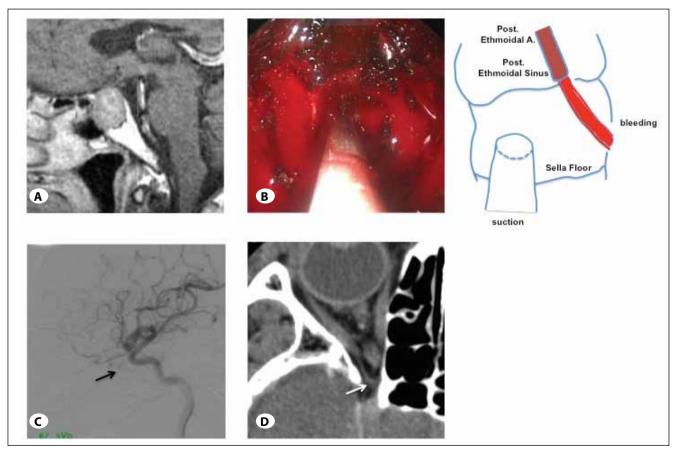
A) Sagittal view of gadolinium (Gd)-enhanced T1-weighted magnetic resonance images (MRI) showing an adenoma extending superior adjacent to the planum sphenoidale. B) Intraoperative endoscopic view showing the posterior ethmoidal artery (PEA) passing through the posterior ethmoidal sinus and actively bleeding (left). Scheme of the intraoperative endoscopic view (right). C) Lateral view of internal carotid artery angiography showed branching of the PEA from the ophthalmic artery and distributing to the posterior ethmoidal sinus. D) Axial view of computed tomography scan with contrast enhancement revealed the PEA passing through the medial wall of the orbit and into the posterior ethmoidal sinus.
